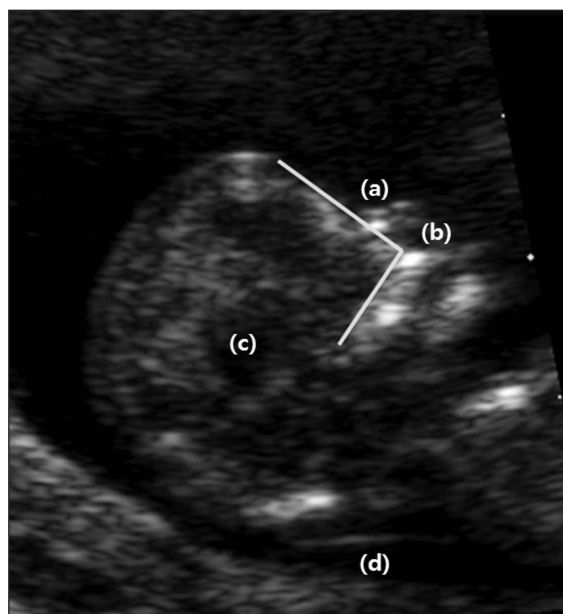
Sonogram showing measurement of the frontomaxillary facial angle. On an image simultaneously depicting the nasal bone (a), diencephalon (b), rectangular maxilla (c), and nuchal membrane (d), the frontomaxillary facial angle was measured between a line drawn on the upper margin of the maxilla and a line drawn from the upper anterior corner of the maxilla to the frontal bone.
